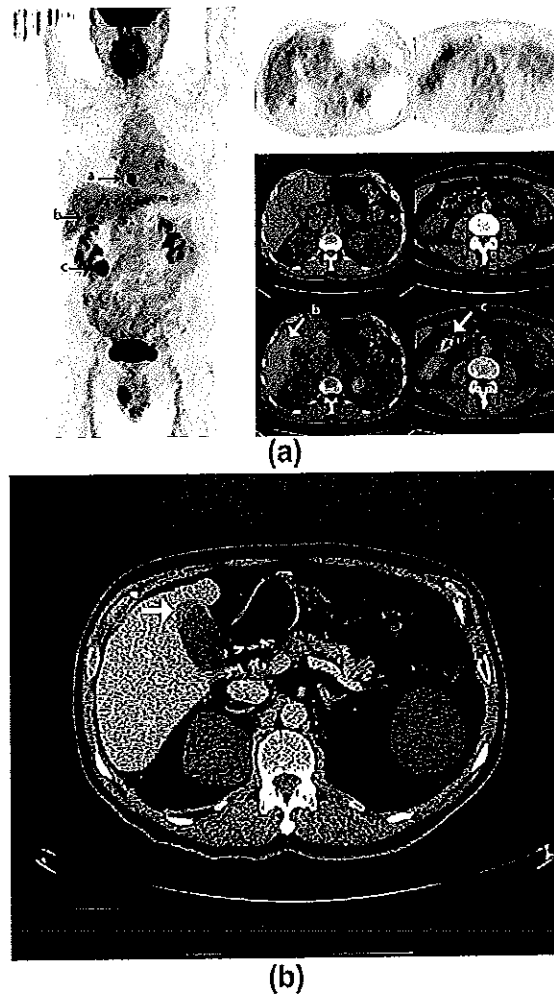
Coincidental detection of colonic polyp and adenomyomatosis of the gall bladder. MIP PET image in a patient with an oesophageal cancer (a) shows focal uptake in the right upper quadrant (b) and in the right paracolic area (c). Selected axial PET, CT, and fused PET/CT images demonstrate that uptake (b) relates to the gall bladder fundus (with focal wall thickening on the contrast-enhanced CT) and uptake (c) localizes to the ascending colon. Cholecystectomy confirmed adenomyomatosis and colonoscopy revealed a 15 mm adenomatous polyp.
